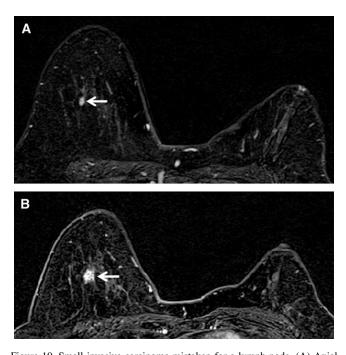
Small invasive carcinoma mistaken for a lymph node. (A) Axial subtracted T1 image of an oval-shaped lesion (arrow), in a high-risk patient, presumed to be a benign lymph node. However, the margins are slightly irregular, and the lesion was not seen on T2 WI, nor was a definite fatty hilum seen. The patient presented 9 months later with a new mammographic finding at the same location. (B) Repeated magnetic resonance imaging, demonstrating enlargement of the lesion with poorly defined margins (arrow); stereotactic biopsy diagnosed a small invasive ductal carcinoma.
